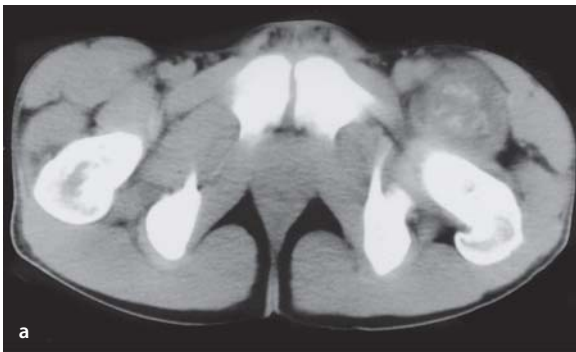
a,b. Myositis ossificans of the proximal thigh in a 12-year-old girl. a Computed tomography (CT). b CT 6 weeks later. Mass with early peripheral calcification in the left iliopsoas muscle (a) and the signs of maturation 6 weeks later (b)
